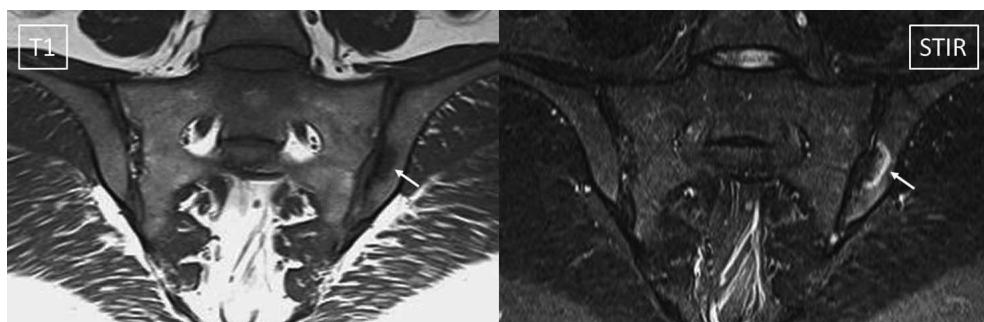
MRI sacroiliac (SI) joints—Osteitis Condensans Ilii (OCI). MRI of SI joints in a 28-year-old female with persistent low back and buttock pain of 4 years duration was performed 1 year after the second pregnancy. C-reactive protein was normal and HLA-B27 was positive. Pelvic radiograph revealed bilateral iliac sclerosis with joint space narrowing and minimal irregularity of the joint surface. The short tau inversion recovery (STIR) sequence shows abnormal increased signal (arrow) in the left iliac bone, with a non-specific appearance. The BMO has an arcuate contour surrounding an area of diminished signal intensity on the T1-weighted sequence (arrow on T1) that corresponded to radiographic sclerosis. More prominent sclerosis and less intense BMO were seen on multiple slices. The subchondral location of the finding may be seen in lesions related to either spondyloarthritis or mechanical causes. The very sharp definition of the borders of the abnormality does not help distinguish the etiology. The T1 sequence did not show evidence of structural damage (erosion, fat metaplasia or ankylosis) except for sclerosis, which is a non-specific observation. The patient was followed up for 10 years and a diagnosis of OCI was subsequently confirmed.
